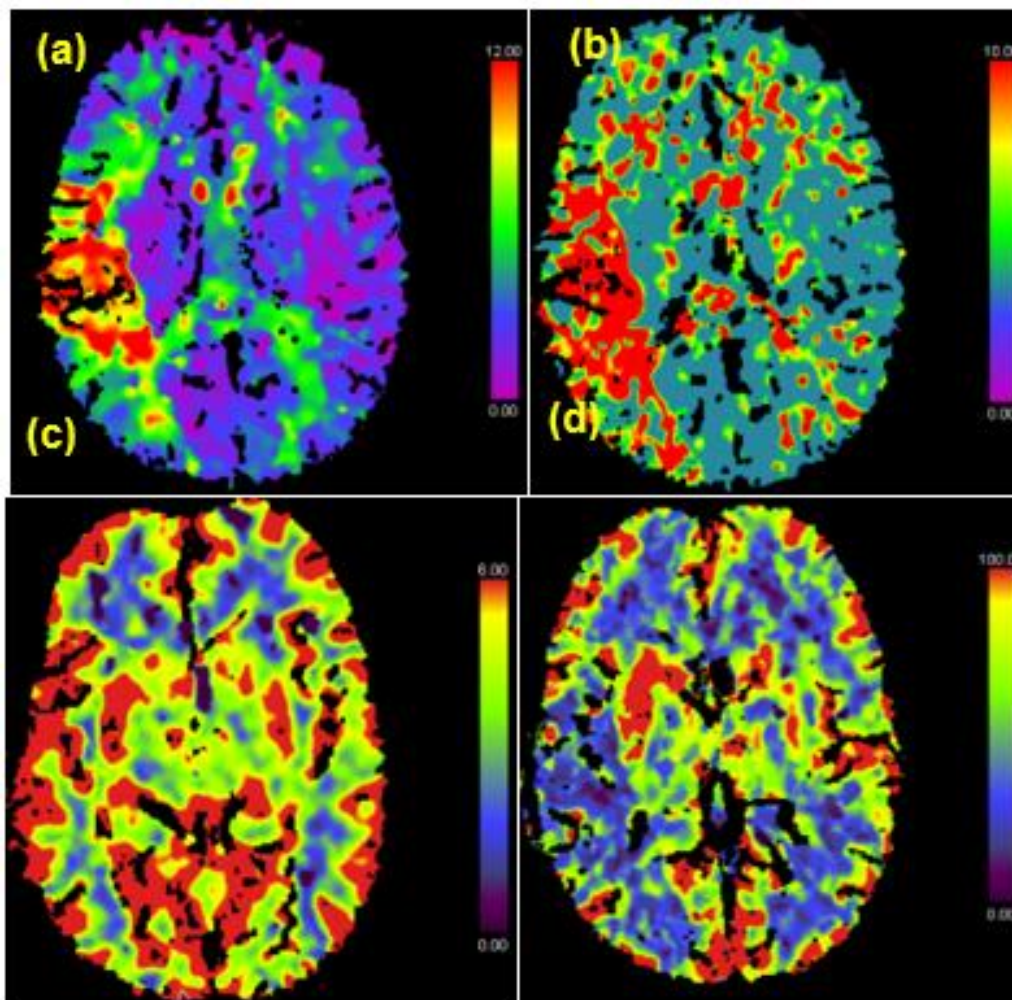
CT perfusion imaging: (a) Tmax, (b) mean transit time (MTT), (c) cerebral blood volume (CBV), and (d) cerebral blood flow (CBF)—demonstrating an area of acute hypoperfusion within the right middle cerebral artery (MCA) territory, featuring a significant perfusion-core mismatch ratio of 4.93 (quantitative parameters summarized in Table 1).
